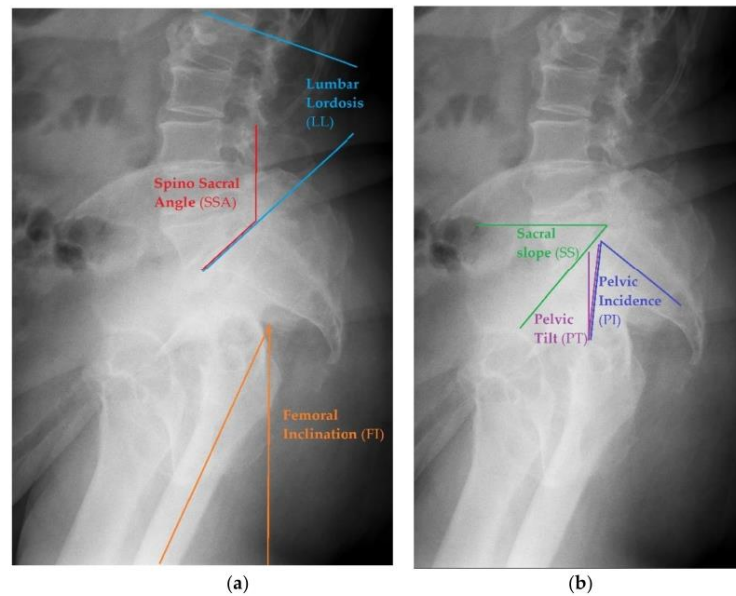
Examples of different pelvic measurements performed on lateral X-rays of the pelvis with lumbar spine view. (a) Spino Sacral Angle, Lumbar Lordosis and femoral Inclination presented on lateral X-ray. (b) Sacral Slope, Pelvic Incidence and Pelvic Tilt presented on lateral X-ray.
